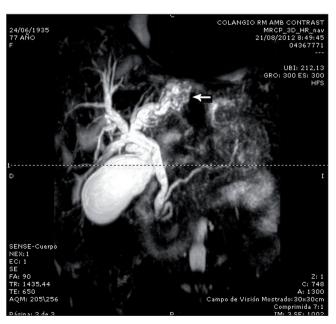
Cholangio-MRI. Beaded dilatation of left segmental bile duct of chronic aspect (arrow).
